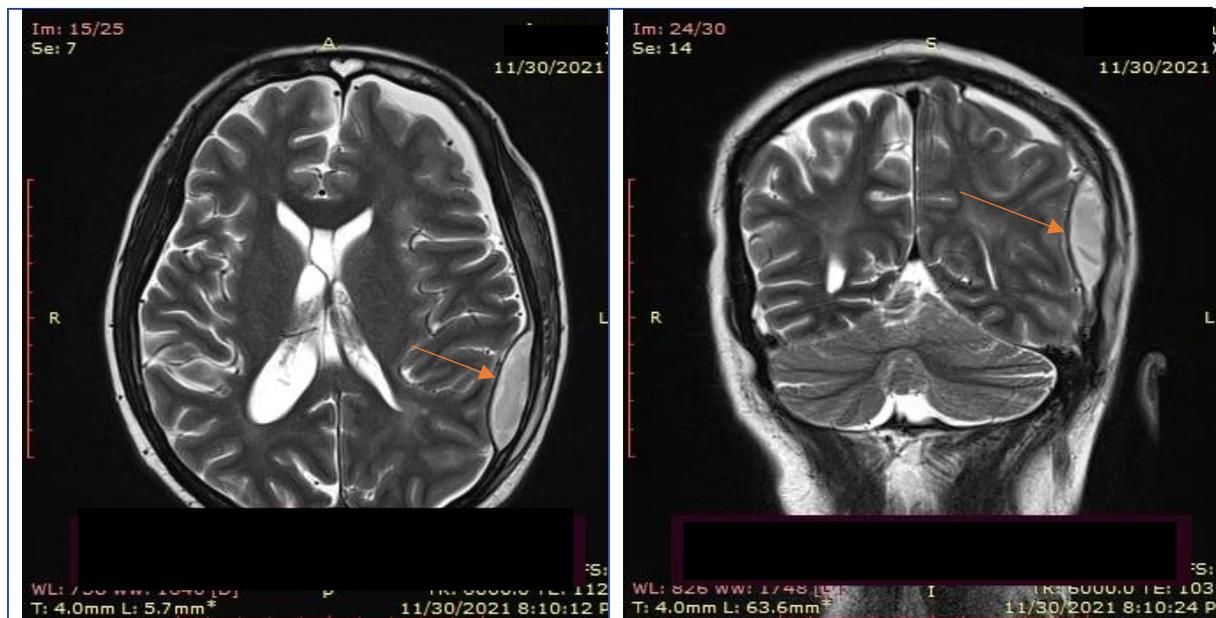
T2 weighted MRI of brain- axial view(left)and coronal view(right) shows lentiform shaped extra axial fluid collection in the subdural space of the left parietal region which exerts a mild mass effect on gyri and sulci. Adjacent meninges are thickened and enhanced.
